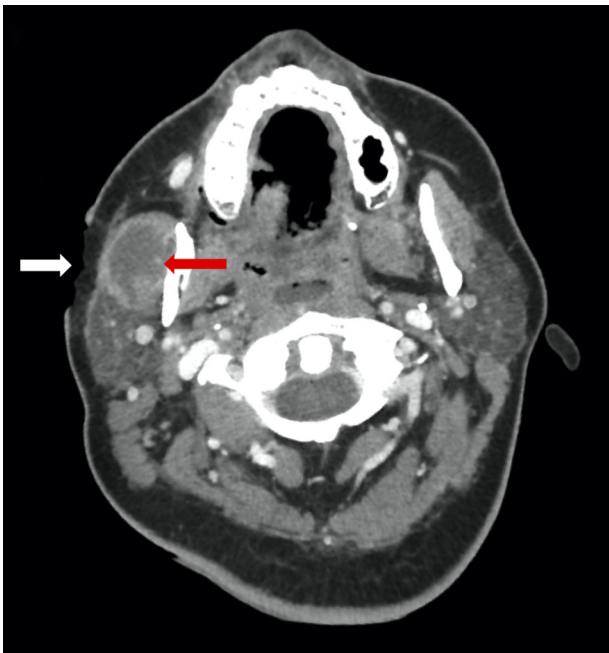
CT-scan of the head; an inflammatory edema of the masseter muscle (red arrow), without abscess at the puncture, is observed next to the cheek pressure ulcer (with arrow).
